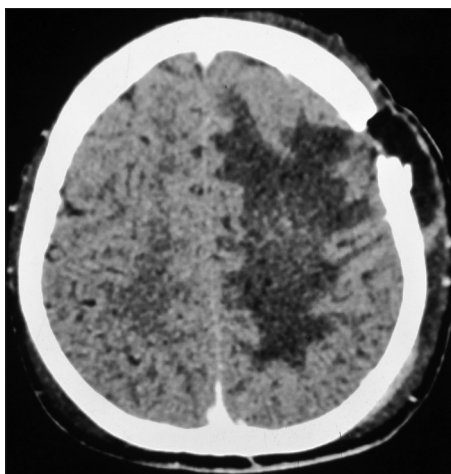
Postoperative CT scan showing complete excision of the lesion
